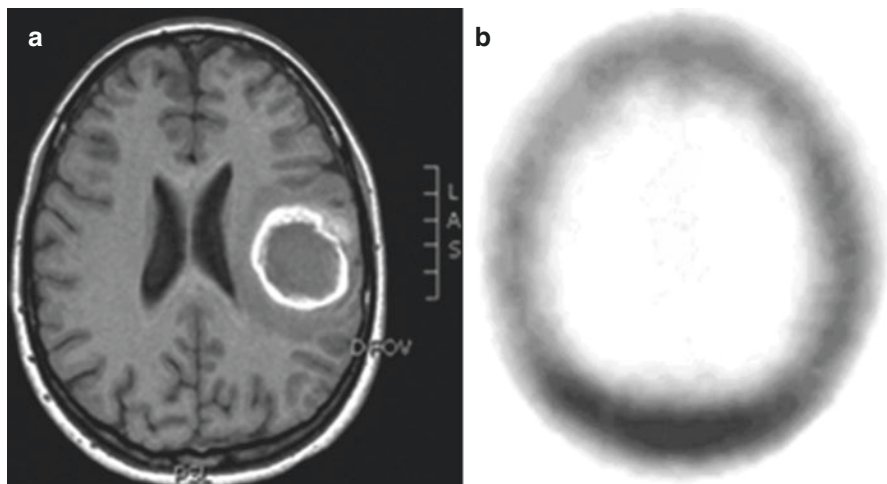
(a) T1-weighted MRI in a patient with an intracerebral hemorrhage. The neoplastic hemorrhagic origin could not be ruled out. (b) Brain SPECT demonstrating no tracer uptake suggesting nonneoplastic hemorrhagic origin
